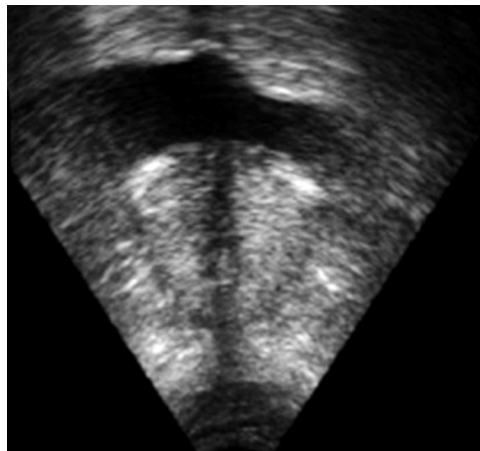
Transperineal ultrasonography for prostate volume
